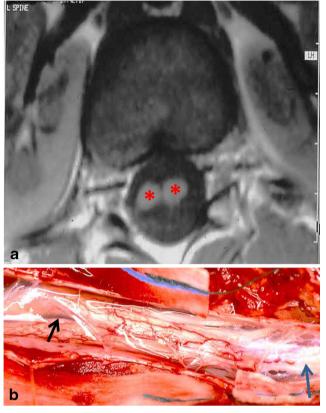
a, b Closed NTD—split cord malformation. a T1- weighted axial MRI study depicts the presence of two spinal cord segments (*asterisk*) within a single dural sheath. Fibrous bands can tether the spinal cord in this form of NTD. b The *black arrow* points to a cleft between the two hemicords that were tethered by fibrous bands. The *blue arrow* points to the enlarged filum terminale containing fat. The filum was divided and a segment of the abnormal filum removed to reduce the chance of retehering
